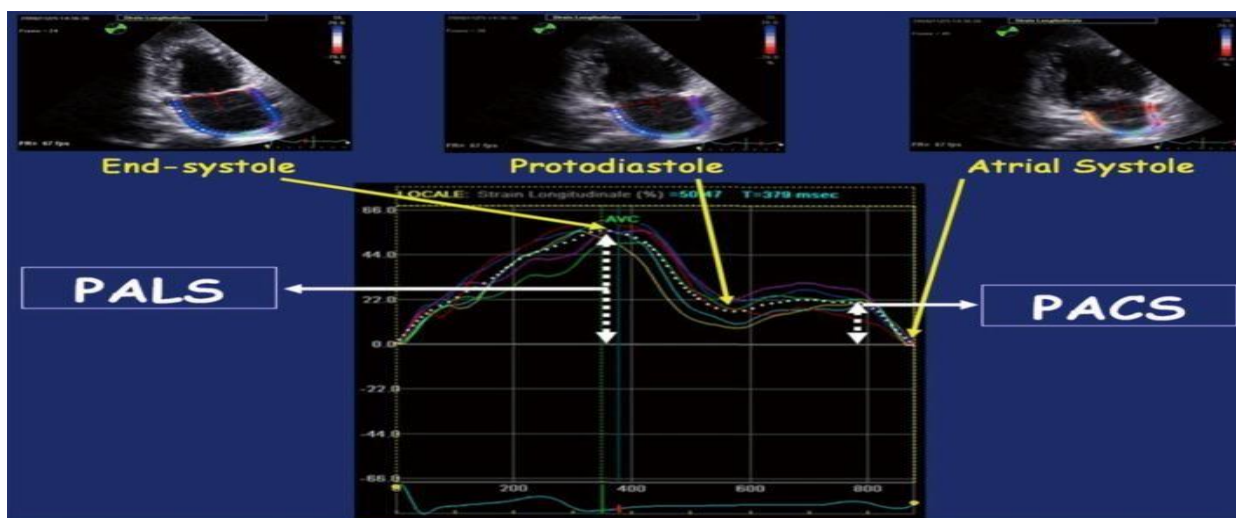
Apical four and two chamber six LA segments. LA, left atrial.
